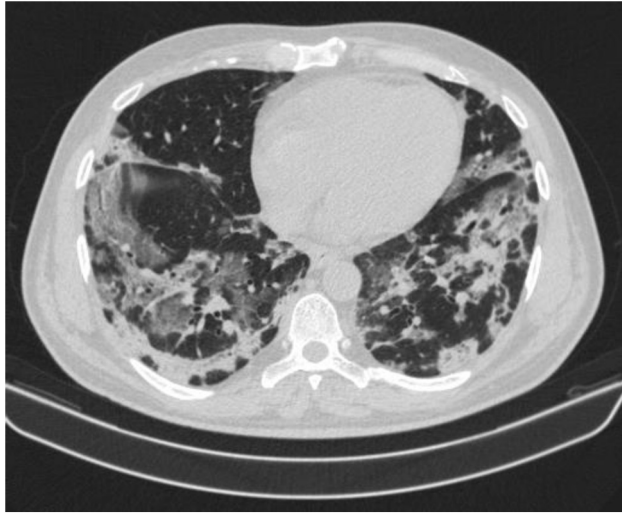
Axial CT scan of the Thorax showing a combination of crazy paving and consolidation.
